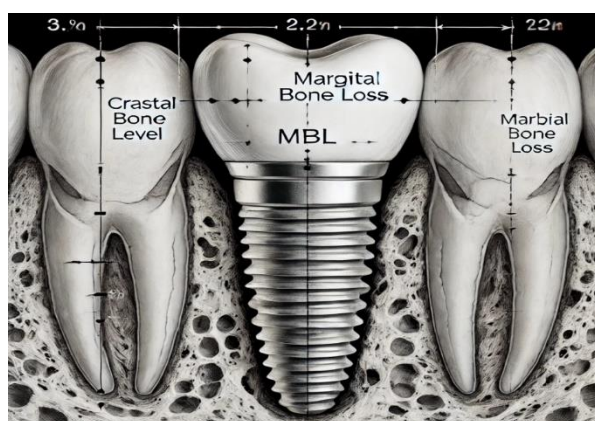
Radiographic Analysis of MBL
